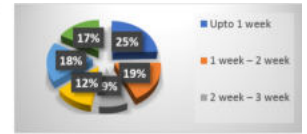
10 Distribution of patients according to duration of symptoms prior to MRI.
